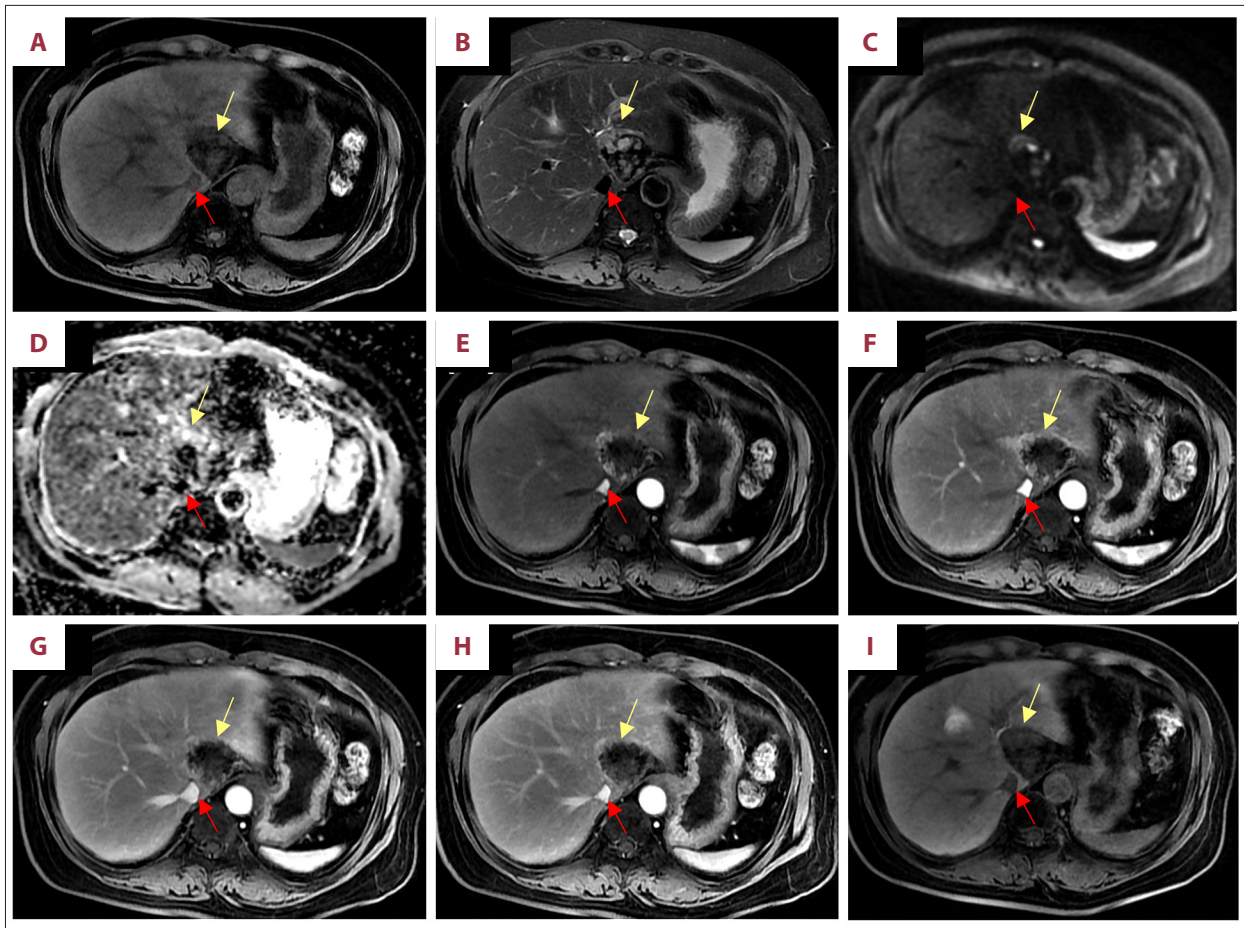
After 2 sessions of transarterial chemoembolization (TACE), MRI shows the following findings. (A) T1-weighted imaging demonstrates mixed hypointensity of the tumor (orange arrow). (B) Fat-suppressed T2-weighted imaging shows mixed hyperintensity. (C, D) Diffusion-weighted imaging ($b=800$ s/mm²) and corresponding apparent diffusion coefficient images demonstrate partial restricted diffusion. (E-H) Dynamic contrast-enhanced MRI shows minimal delayed peripheral enhancement, with a marked reduction in the enhancing area compared with prior imaging. (I) On hepatobiliary phase imaging, the lesion is hypointense relative to the background liver parenchyma, with focal isointense areas at the tumor margins. The tumor (orange arrow) is clearly demarcated from the inferior vena cava (red arrow).
